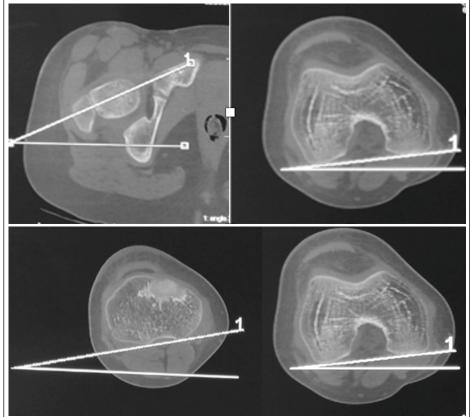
(a) Computed tomography (CT) scan evaluation of torsion of femur. (b) CT scan evaluation of torsion of tibia.
